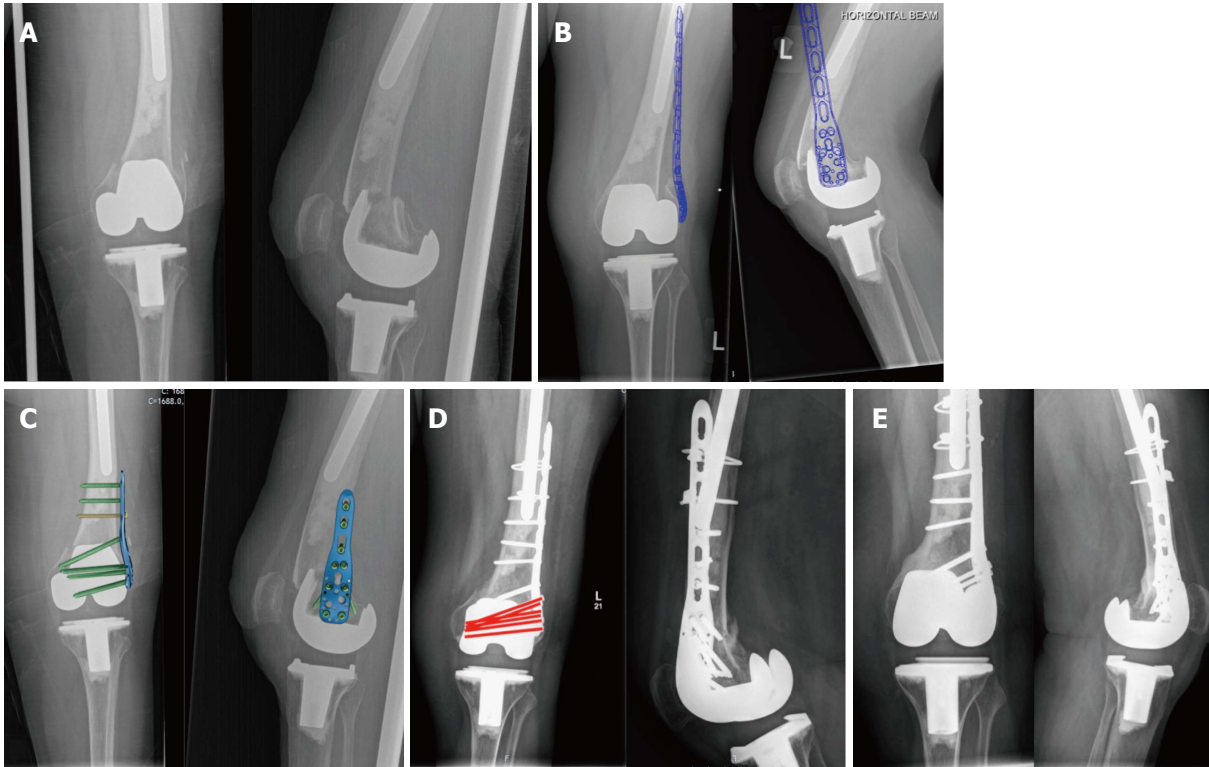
Radiograph series of patient A. A: Anteroposterior and lateral injury radiographs; B: Templated anteroposterior radiograph showing proposed position of implant; C: Anteroposterior and lateral radiographs with PHILOS plate image superimposed to show orientation of screws; D: Post-operative radiographs at 6 mo with orientation of screws behind the femoral component shown in red; E: Anteroposterior and lateral radiographs at 19 mo post-op.
